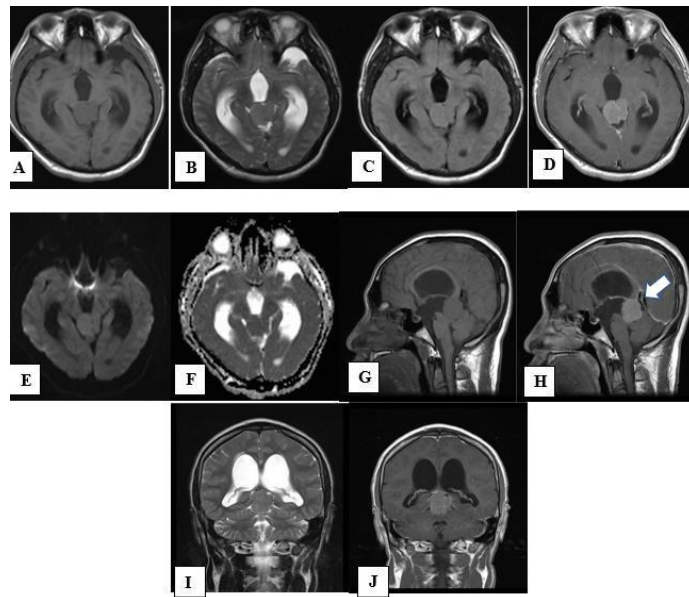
Brain MRI. (A) Axial T1-weighted, (B) Axial T2-weighted, (C) Axial FLAIR, (D) Axial T1weighted + gadolinium contrast, (E) Axial DWI, (F) Axial ADC image, (G) Sagittal T1-weighted, (H) Sagittal T1-weighted + gadolinium contrast, (I) Coronal T2-weighted, (J) Coronal T1-weighted + gadolinium contrast. Note that the tumor originated just beneath the anterior edge of the tentorium, near to the junction of galen vein and the straight sinus (white arrow), with a dural adherence apparent after contrast injection.
